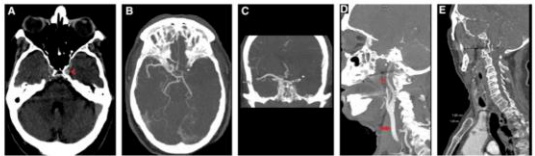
a Unenhanced brain CT, showing a hyperdense intracranial left internal carotid artery in its petrous segment. b and c CT angiography of the cerebral arteries (arch to vertex protocol). Axial (B) and Coronal (C) MIP reconstruction showing a complete filling defect after the petrous segment of the left carotid artery, and an absence of the left middle cerebral artery. d CT angiography of the cerebral arteries (arch to vertex protocol). MIP reconstruction showing the left common carotid artery (red arrow) and the internal carotid artery (red arrowhead), with a prominent carotid bulb and calcified atherosclerotic plaques with no signs of lumen narrowing or wall thickening. e CT angiography of the carotid and cerebral arteries MIP reconstruction. Incidental finding of two floating thrombi of around 10 mm, in the ascending aorta, just before the origin of the right brachiocephalic artery
